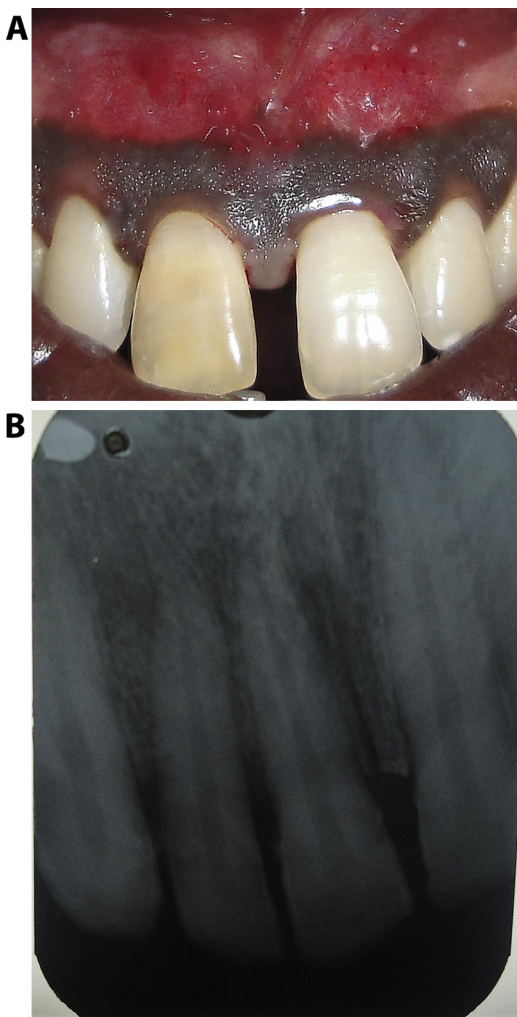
(a) Healing of the recipient site 12 months postoperatively. (b) Radiographic examination after 12 months post-op revealing bone fill.
